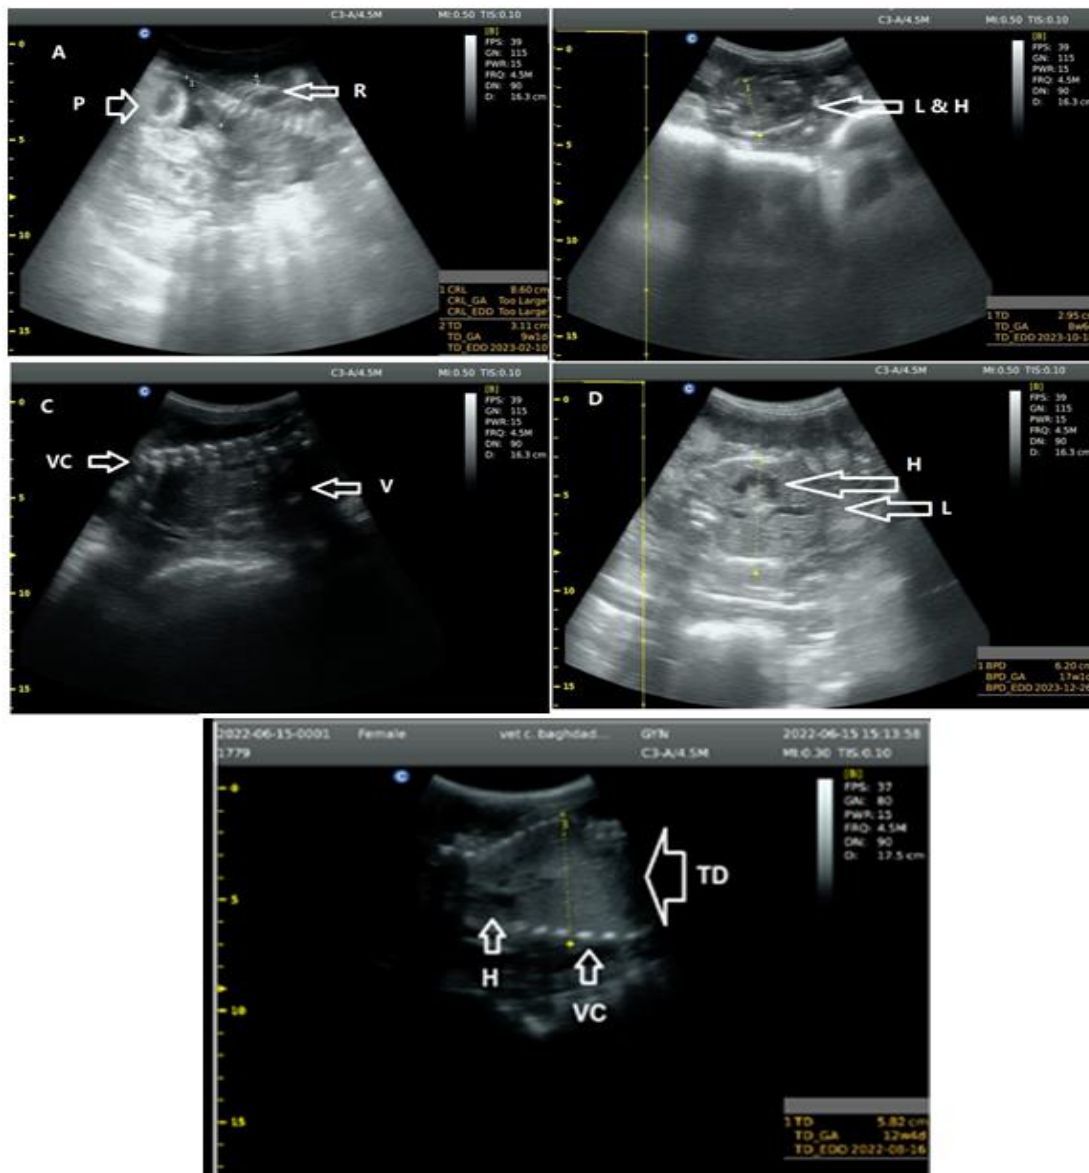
Transabdominal ultrasonography images showing fetal Ribs (R), lung (L), heart (H), Vertebral Column (VC) and thoracic cavity.
